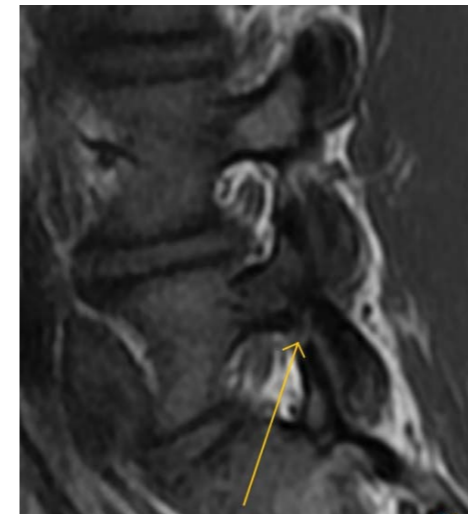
MRI Sagittal T1. Incomplete L5 pars stress fracture.
